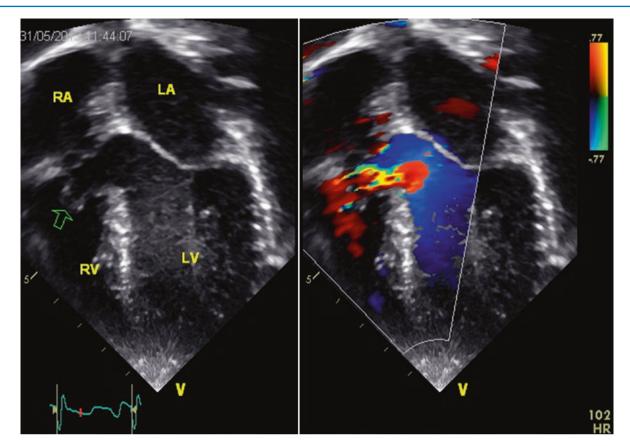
Echo image: perimembranous VSD with aneurysmal membranous septum (apical four chambers view)
